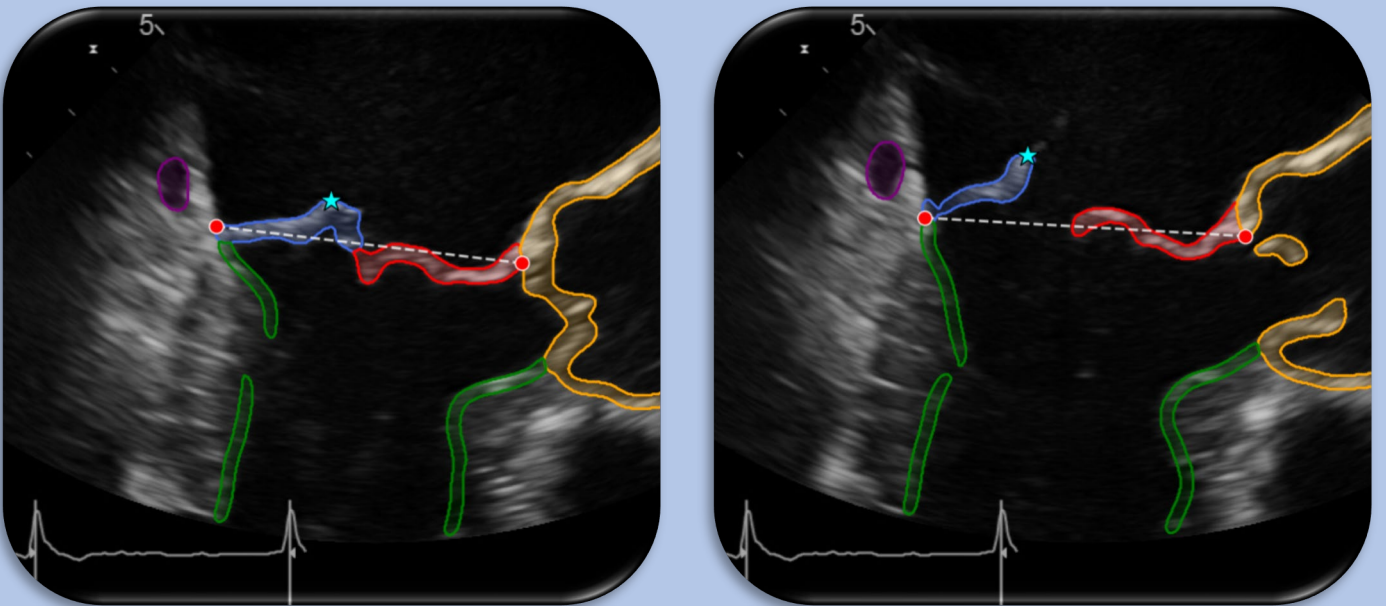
represent a patient with a P2 prolapse of the mitral valve. In this case, the prolapse was successfully identified by the algorithm using intraoperative echocardiography. These automated findings were consistent with the intraoperative surgical report
